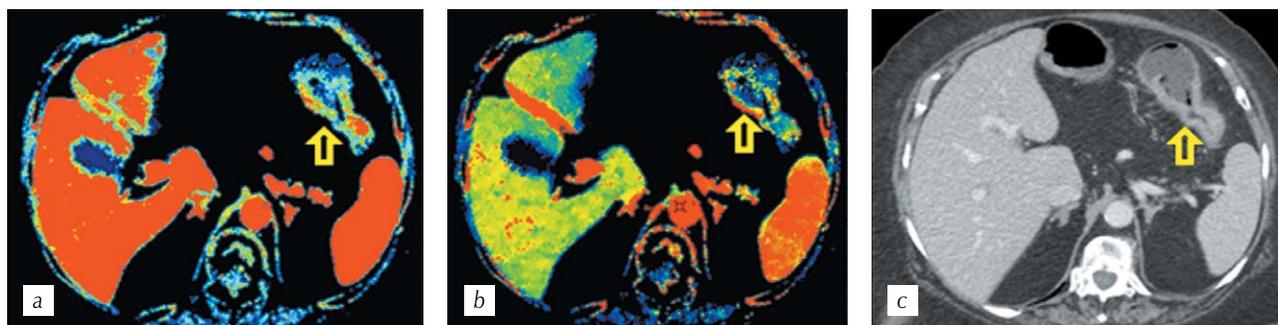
CT perfusion (*a, b*). Parametric maps: *a* — volume and *b* — blood flow showing pathological increased blood flow in the descending colon tumor (arrows); *c* — HCT. Multiplanar reconstruction in the axial plane in the portal phase of scanning
